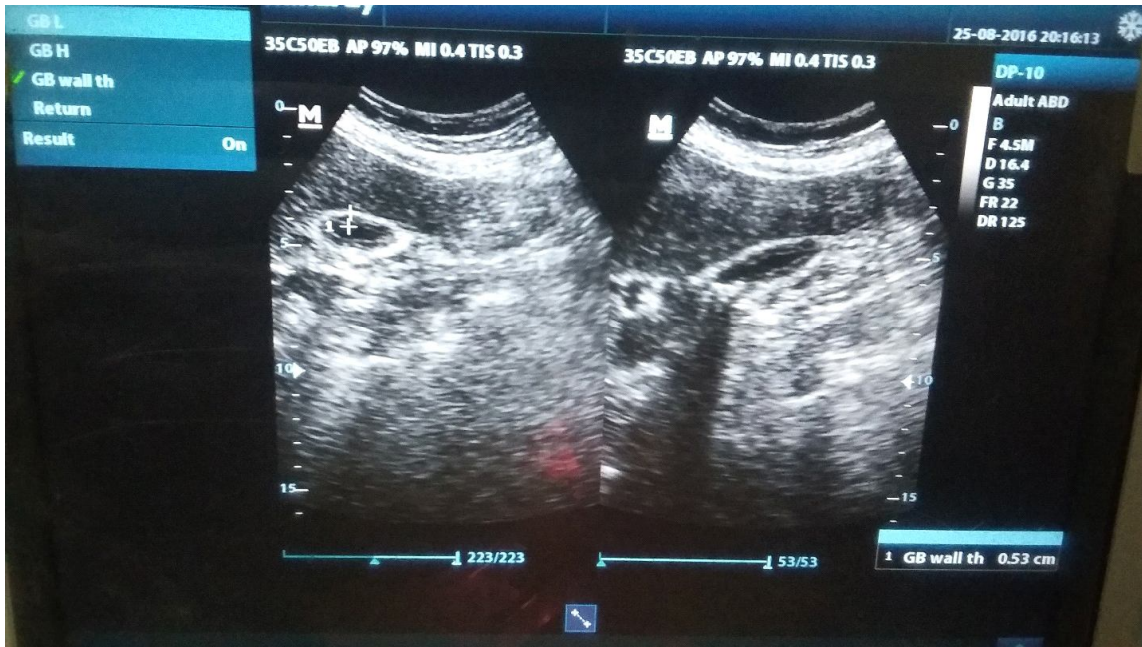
Ultrasound image of 60 years female showing calculus cholecystitis.
